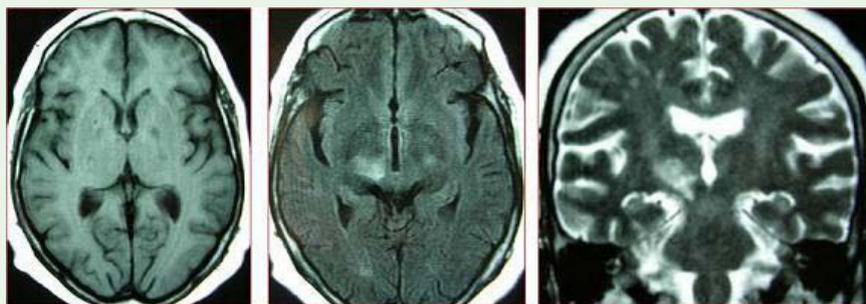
a) T1 MRI showing no obvious thalamic lesion b) High signal lesion in axial FLAIR images on the right diencephalic – upper brainstem area c) Coronal T2 image showing the same high signal thalamic lesion.
